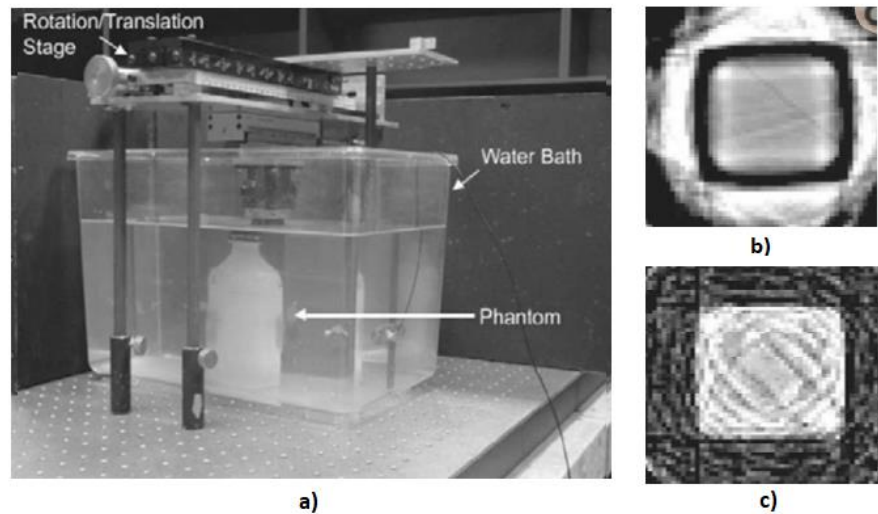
Ultrasound scanner with translational mechanism (a); acquired transmission image (b); image, acquired using TOF method (c) [4].
